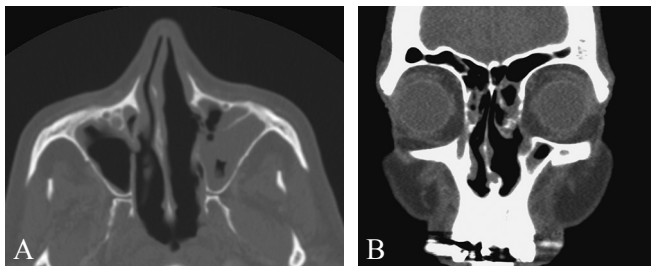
Axial (A) and coronal (B) postoperative CT images 6 months after surgery confirming the optimal healing and the absence of recurrence.
